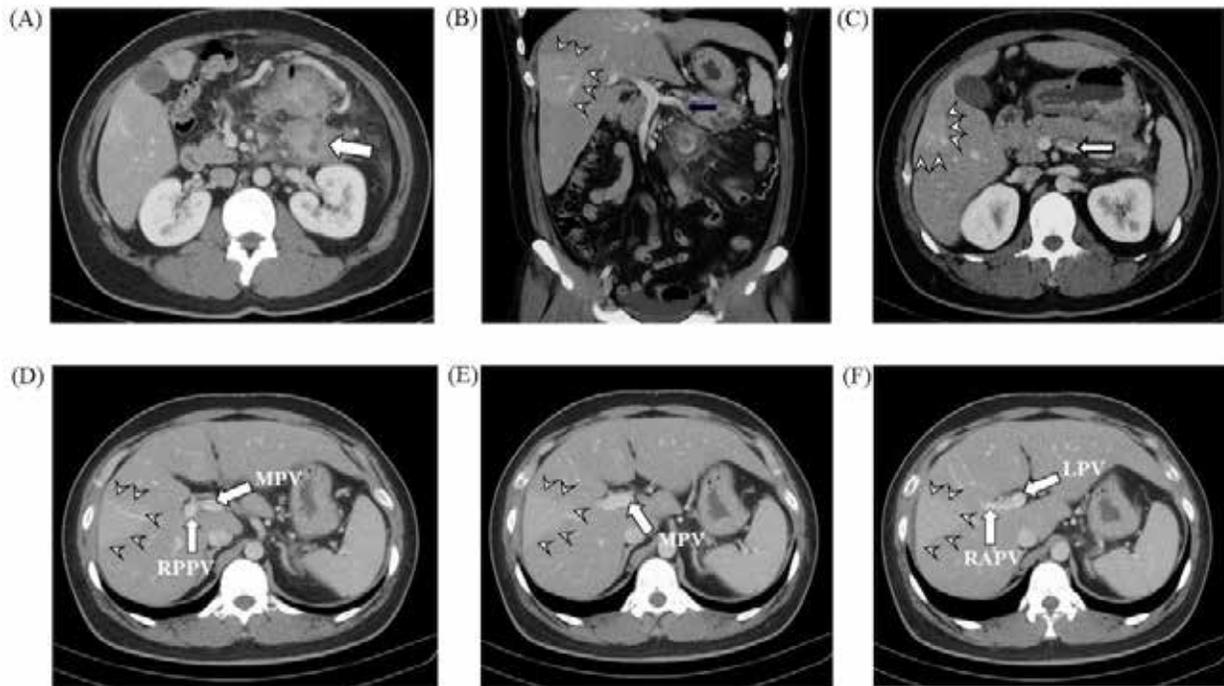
Contrast-enhanced CT shows: (A) A small abscess in the left mesenteric root region with an extensive adjacent proximal jejunum and distal transverse colon swelling (arrow). (B) Coronal view and (C) axial view of partial thrombosis in the splenic vein (arrow) and transient hepatic attenuation differences (THAD) lesion (arrowheads). (D), (E), (F) Arrowhead indicates transient hepatic attenuation differences (THAD) lesion in S8 of the liver and type II anatomic variation is demonstrated. MPV: main portal vein; LPV: left portal vein; RPPV: right posterior portal vein; RAPV: right anterior portal vein
